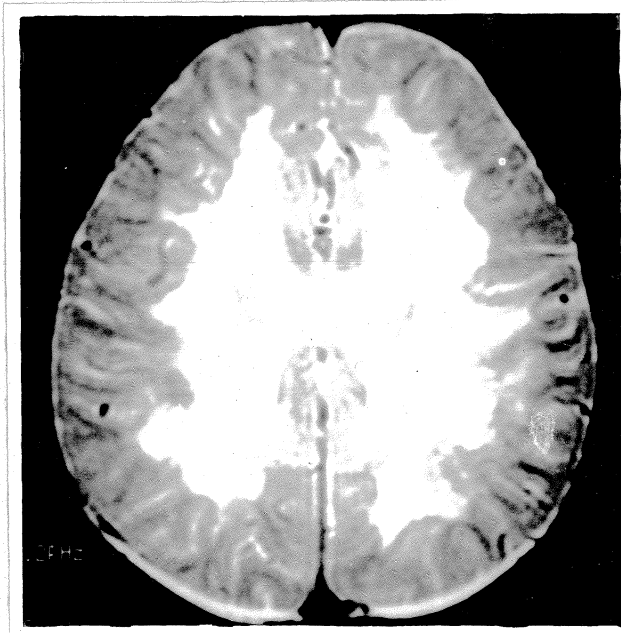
Diffuse dysmyelination in case of 6 yr old boy with MLD. (MRI-T₂WI)
